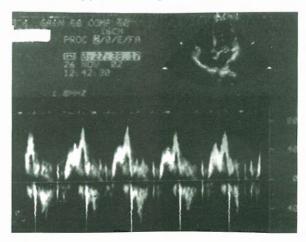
The patient's baseline mitral inflow pulse-wave Doppler examination showing abnormal relaxation pattern of diastolic dysfunction
